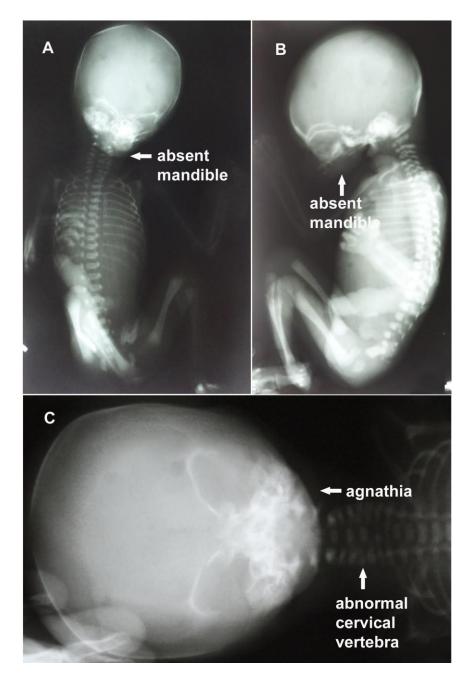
A & B: X-Ray of the fetus – Antero-posterior (AP) & Lateral views; 9C: X-Ray – AP view of the head and neck.
